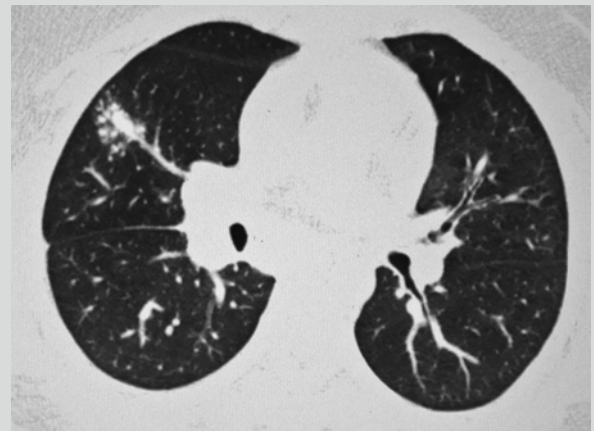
Primary syndrome. CT scanning demonstrates a small quantity of spot-like shadows at the lateral segment of the right middle lobe with fusion of some spot-like shadows, enlarged right hilum that is caused by right hilar lymphadenectasis, and unobstructed adjacent bronchus
